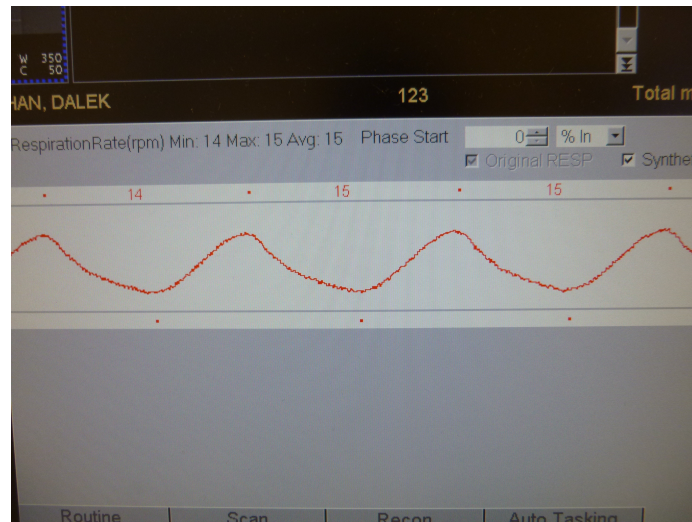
A smooth respiratory wave taken from the CT control monitor. The red dots which represent phase end points are well placed.
